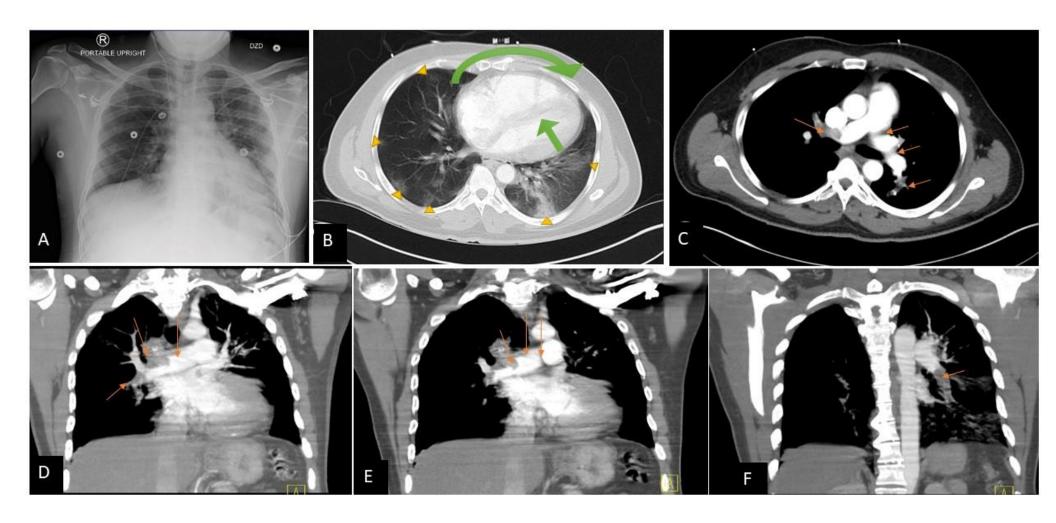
Anterior Posterior (AP) chest radiograph and coronal and axial computed tomography angiography (CTA). Panel A shows portable upright chest radiograph obtained on admission showing patchy multifocal infiltrates in the left mid and lower lung consistent with viral pneumonia and right internal jugular catheter noted with the distal tip in the right atrium. Panel B (yellow triangles) shows bilateral peripheral ground-glass opacities on lung window. Green arrows denote clockwise rotation, bowing (P-sign) and flattening of the interventricular septum, consistent with right heart strain. The RV/LV ratio is approximately 1.8 Panels C-F shows axial and coronal CTAs with orange arrows denoting bilateral pulmonary embolisms.
